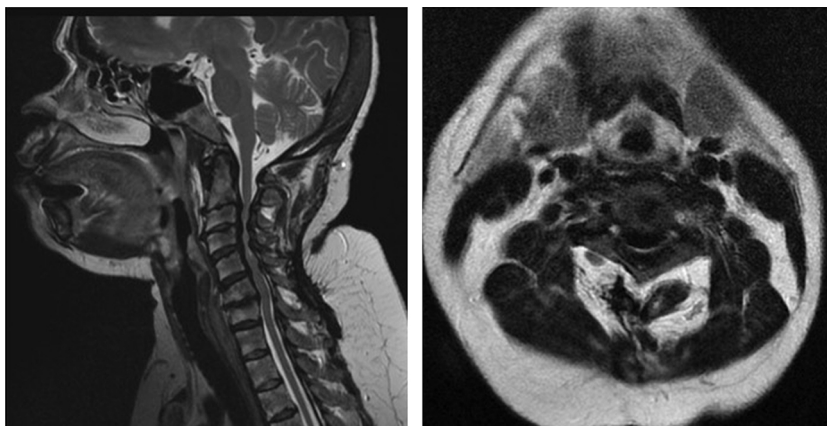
Preoperative sagittal (left) and axial (right) T2-weighted MRI showing severe cervical stenosis from C3 to C6 due to hypertrophic ligamentum flavum in a 53-year-old female patient with chronic renal failure and progressive motor deficit in the lower limbs.
